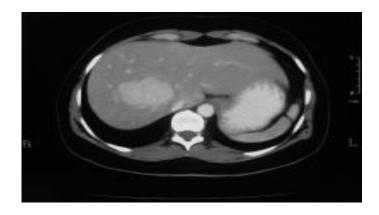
Enhanced axial CT scan through the liver in the arterial phase in a 38-year-old woman referred for gallbladder scanning. The mass demonstrates intense enhancement.
